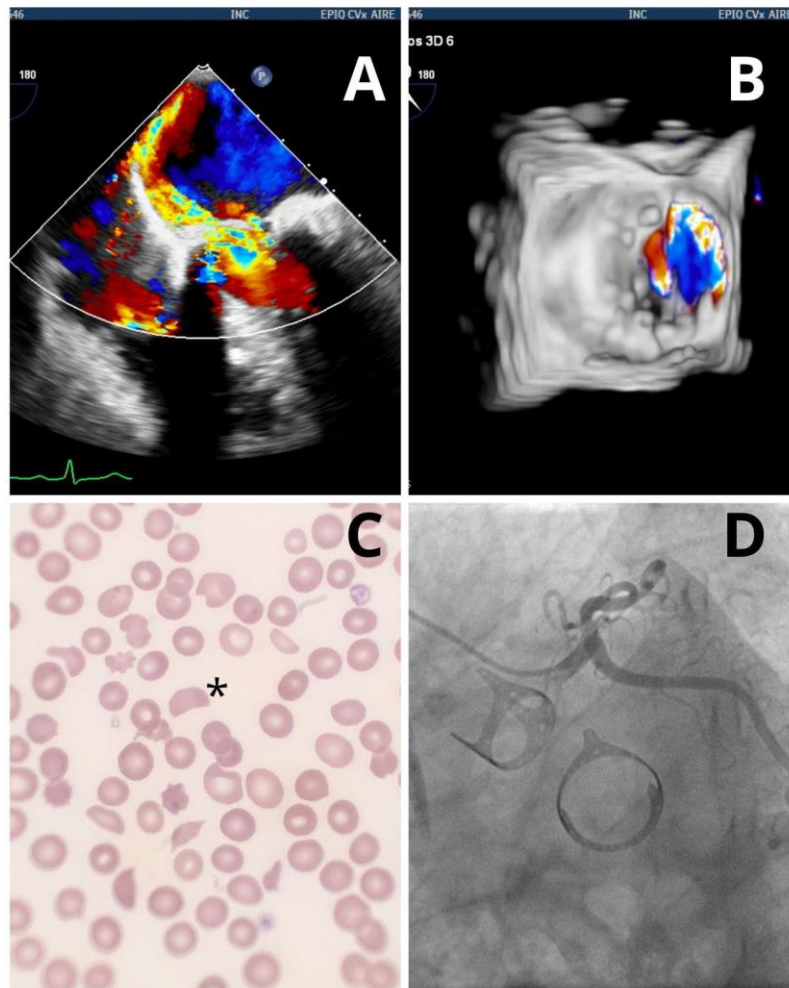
A) Transesophageal echocardiogram with severe mitral regurgitation, B) reconstruction of severe mitral regurgitation, C) Peripheral smear with schistocytes * D) angiography with mitral and aortic bioprosthesis.
